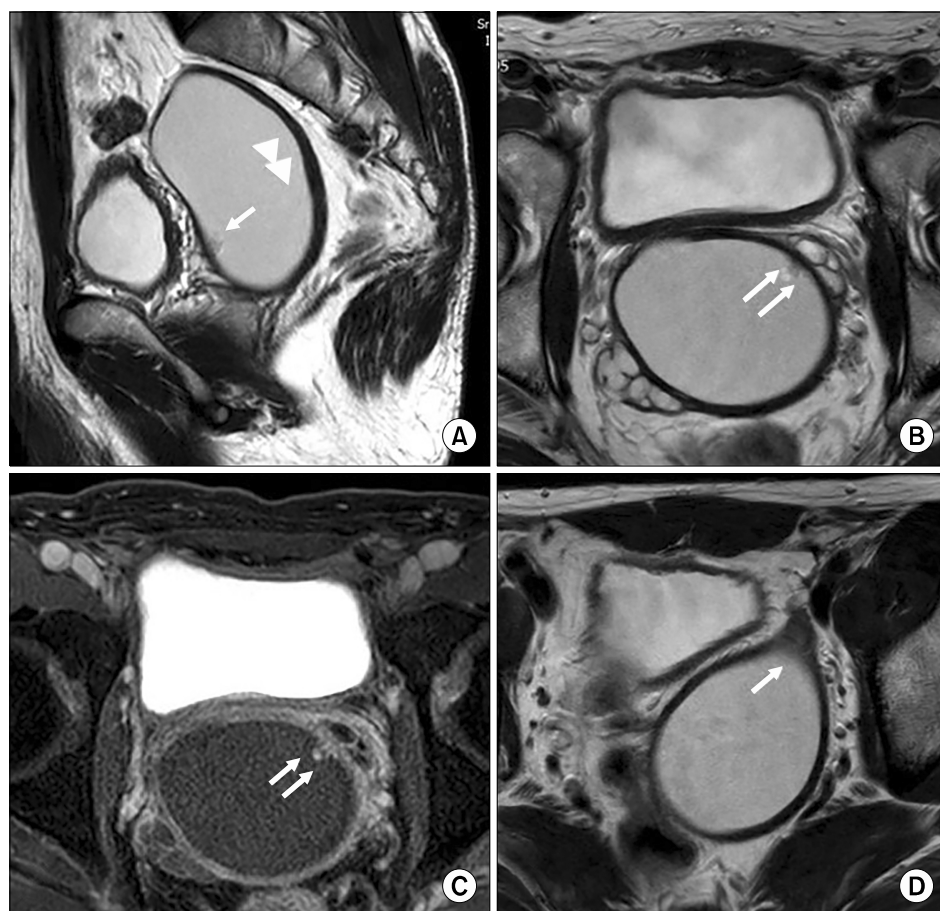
Magnetic resonance images of a 40-year-old man. (A) The sagittal T2 weighted image showed a large T2 hyperintense cyst with a thickened T2 hypointense wall (arrowheads). A small T2 hyperintense nodule was shown at the anterior wall (arrow). (B) An axial T2 weighted image showed a large T2 hyperintense cyst with several T2 mild hyperintense polypoid nodules (arrows). (C) An enhanced axial T1 weighted image showed enhancing papillary lesions (arrows). (D) An axial T2 weighted image showed that the lesion originated from the left seminal vesicle (arrow).
